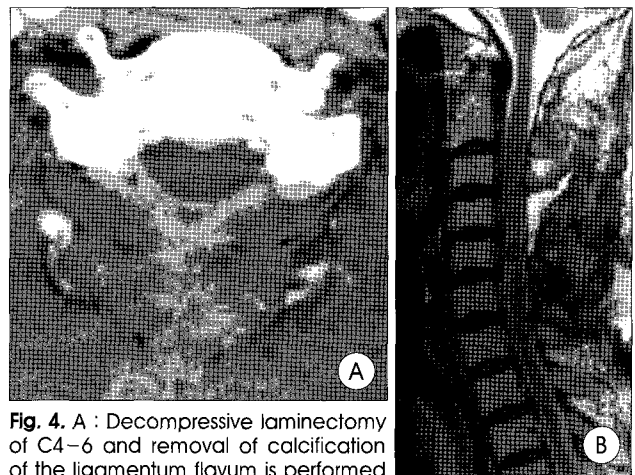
A : Decompressive laminectomy of C4-6 and removal of calcification of the ligamentum flavum is performed in computed tomography scan. B : Cord compression is marked improved after operation but intramedullary signal change in T2-weighted sagittal imaging is still remained.
